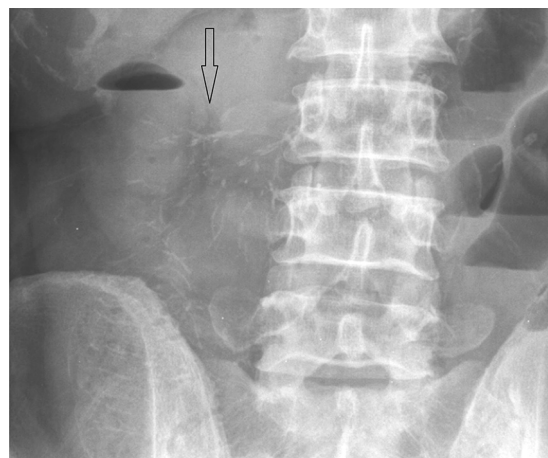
A plain abdominal radiograph depicting diffuse treelike calcified plaques in the superior mesentery vein and its branches (arrow).
